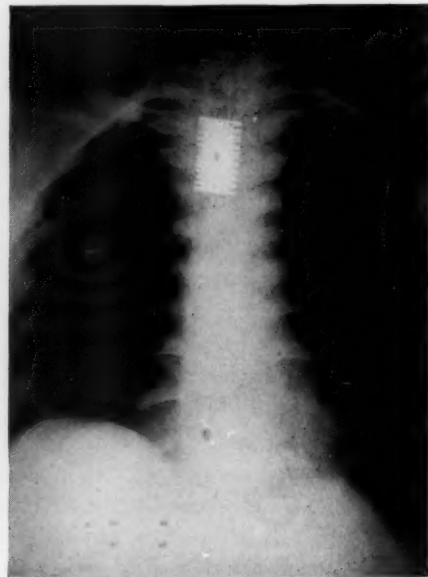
Roentgenogram showing a razor guard in the esophagus at the level of the transverse arch of the aorta.
